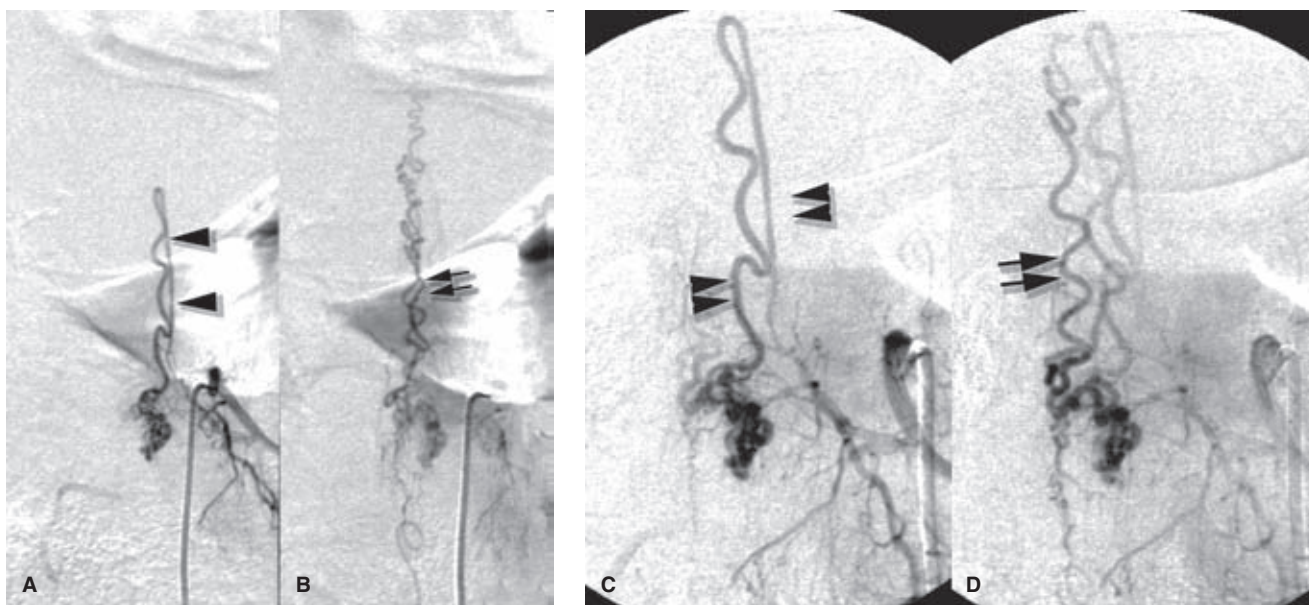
(A–D) Perimedullary spinal arteriovenous malformation. An elderly male presented with a clinical history of gait disturbance and urinary incontinence. MRI and myelographic findings (not shown) suggested spinal venous hypertension. A left T12 injection demonstrates an enlarged posterior spinal artery (*arrowheads in A*) supplying a perimedullary arteriovenous malformation of the surface of the cord. The early venous phase of the PA view (B) shows drainage of the arteriovenous malformation superiorly through the tortuous venous plexus of the spine. An oblique magnification view of the same pedicle (C, early; D, late) helps to clarify the surgical anatomy. The posterior spinal artery (*arrowheads in C*) behind the cord makes a hairpin turn on the posterior surface to supply the perimedullary nidus. A slightly later image (D), taken when the posterior spinal artery is almost washed out, demonstrates the most prominent vein (*double arrow in D*) draining along the surface of the cord.
